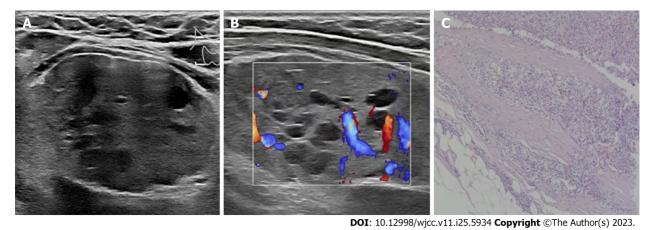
Parathyroid adenocarcinoma of the lower right lobe of the thyroid gland in a 28-year-old woman. A: Doppler ultrasound revealed a solid nodule with small internal cystic foci; B: Color doppler flow imaging indicated multiple streaks of blood flow signals were observed in the solid part of the nodule; C: Parathyroid chief cells with neoplastic hyperplasia; some of the tumor cells were atypical, and the tumor capsule was of different thicknesses with focal capsule invasion.
